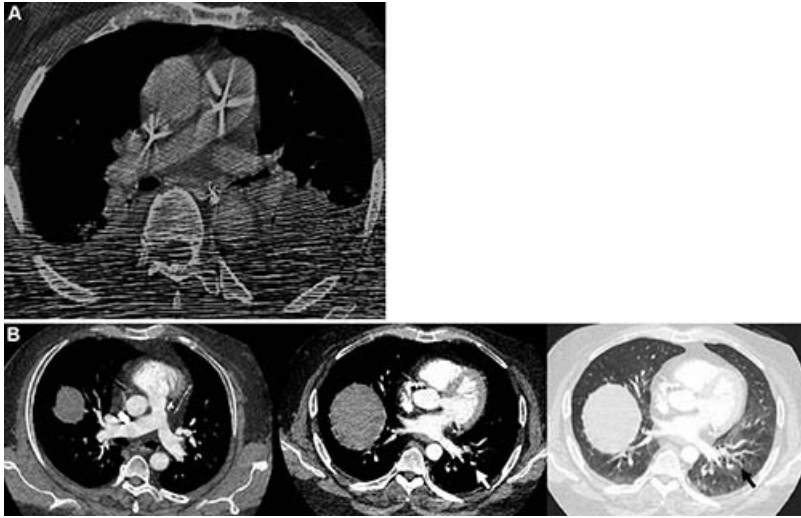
Image quality modifications. (A) Non-diagnostic axial CT angiography image quality with inability to exclude presence of acute pulmonary embolus in the central vessels, Pulmonary Embolism Reporting and Data System (PE-RADS) N. (B) Limited axial CT angiography image quality, no acute pulmonary embolism identified in the central vessels with incomplete assessment of segmental and/or subsegmental vessels due to motion artifact (arrows), PE-RADS 0L.
